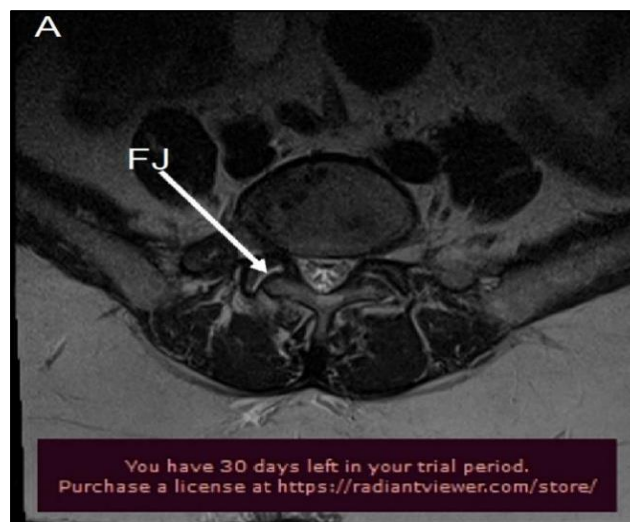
MRI axial view of the lumbar spine showing facet joint erosion
